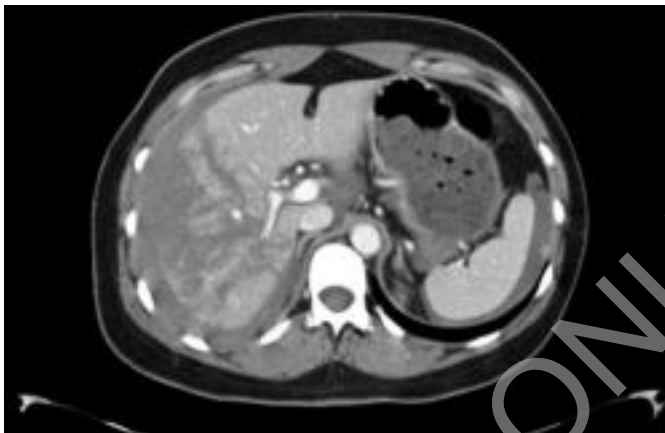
CT scan showing a large liver laceration affecting V, VI and VII segments, associated with intraperitoneal perihepatic hemorrhage.
